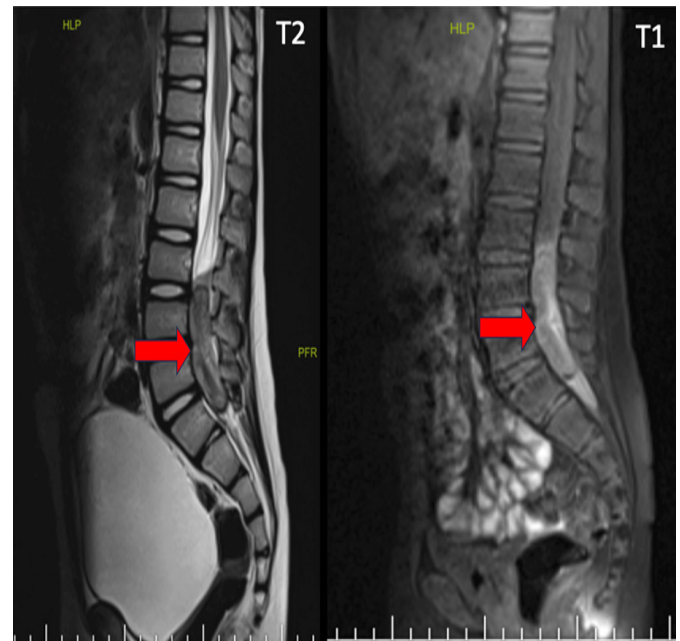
Lumbar magnetic resonance imaging a) T2 sequence showing an intradural extra-axial mass with heterogeneous hypointense signals in the spinal canal at the L4-L5-S1 level and a globular bladder appearance b) T1 sequence showing heterogeneous enhancement of the mass at the L4-L5-S1 level.
